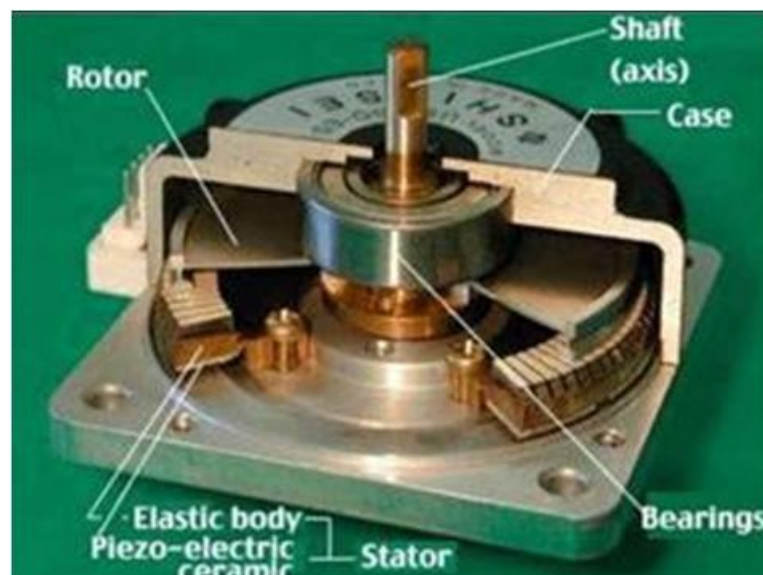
Cross-sectional view of an ultrasonic USR-60 non-magnetic motor [Shinsei, 2005].
